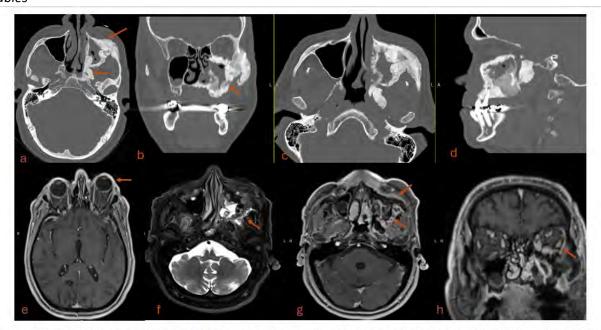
Axial CT scan of the nasal sinuses (a) shows an expansile sclerotic lesion involving the left maxillary sinus, hard palate, inferior wall of the left orbit, zygoma, pterygoid plate, and greater wing of the sphenoid bone. A follow-up CT scan taken one year later (b, c, and d) reveals further enlargement of the expansile lesion with increased bone destruction. MRI of the head with contrast (f, g, and h) demonstrates an enhancing soft tissue component with intra-orbital extension. Note the left eye proptosis (e).
